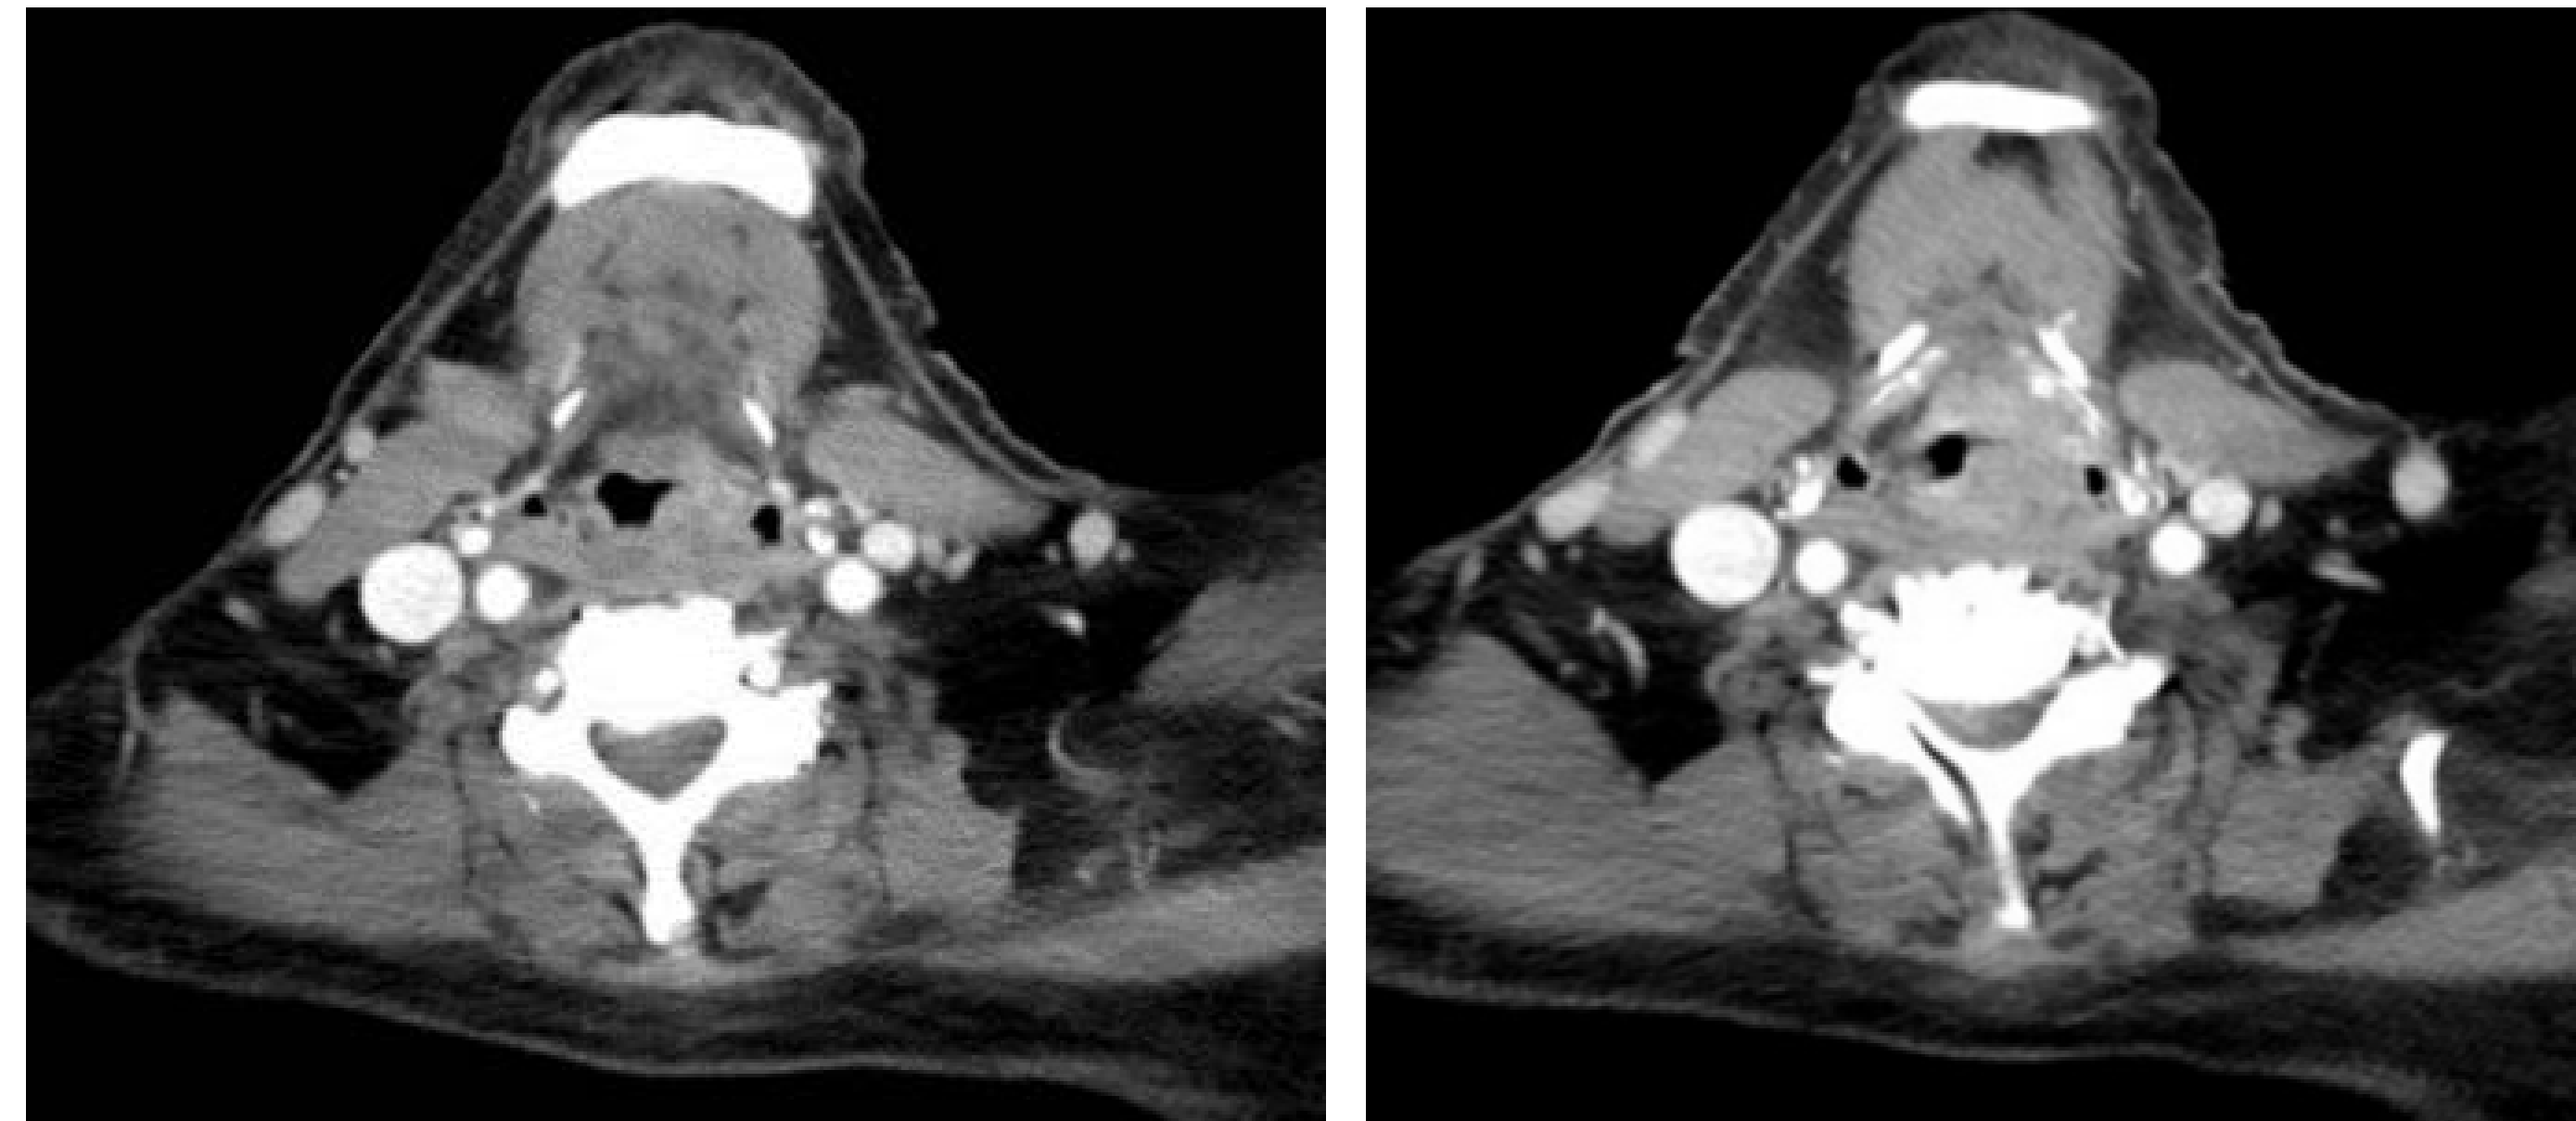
Axial CT Neck with contrast demonstrating mass extending from left wall of the larynx with partial obstruction of the airway
